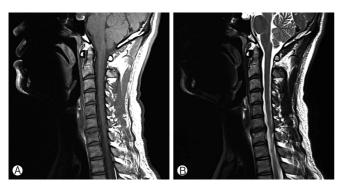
Modic change type I at C6-7 as a low signal in a T1-weighted image (A) and a high signal in a T2-weighted image (B).
